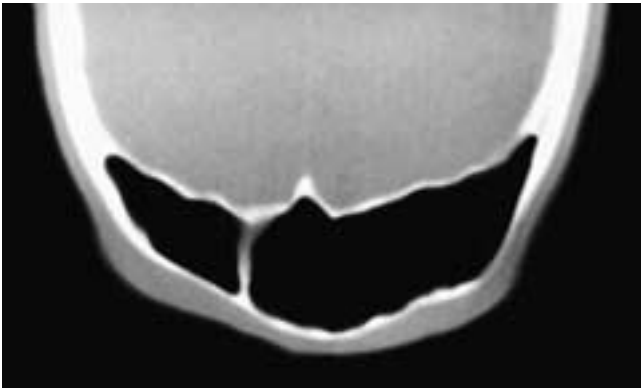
Coronal CT scan shows a very large, normally aerated frontal sinus. Despite its size, there was no bossing of the forehead or remodeling of the inner table. This patient had a hypersinus.
